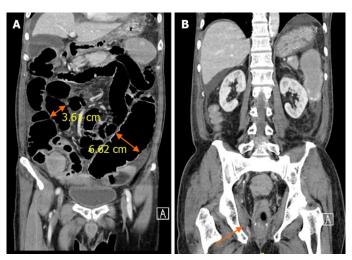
Computed tomography image of the abdomen and pelvis on coronal axis. A: Dilated small (3.61 cm) and large (6.62 cm) bowel loops; B: Smooth tapering of bowel towards the neorectum (highlighted by the arrow).
